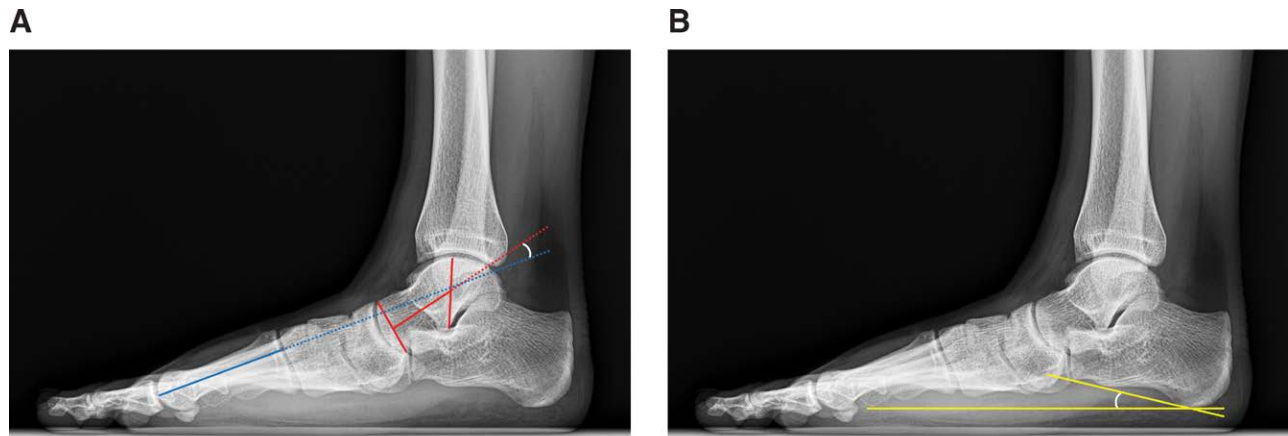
Standard weight-bearing lateral radiograph angle measurements of the foot. (A) Talo-first metatarsal angle. (B) Calcaneal pitch angle.
